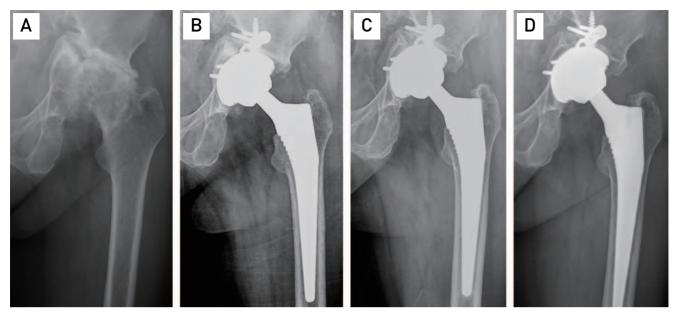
(A) A 66-year-old female patient had previous pelvic trauma on the left hip. She had a pelvic fracture and hip joint dislocation 16 years ago, which were treated conservatively. (B) She underwent total hip arthroplasty. Nonunion of the acetabular fracture was fixed with a plate and the cup center was medialized. Postoperative 6-week radiograph. (C, D) Radiographs at postoperative one year (C) and six years (D).
